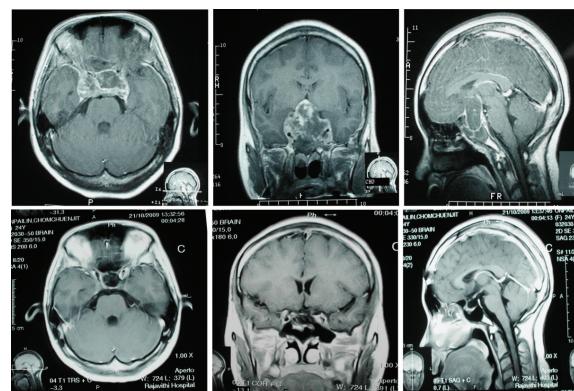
T₁-weighted contrast enhanced MRI in axial, coronal, and sagittal view of case 2
